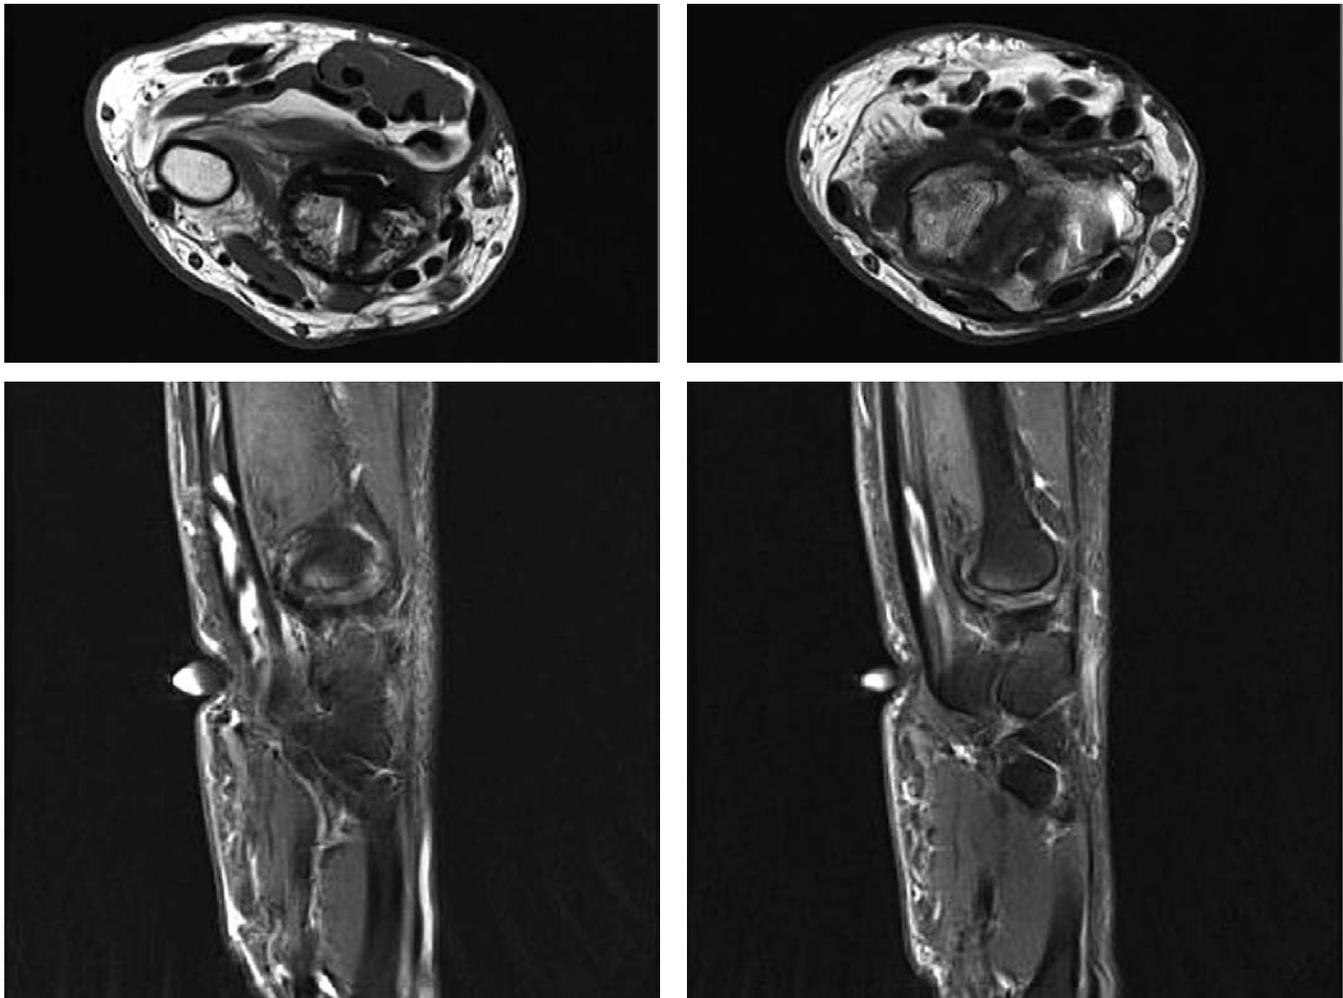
Postoperative MRI Images.
